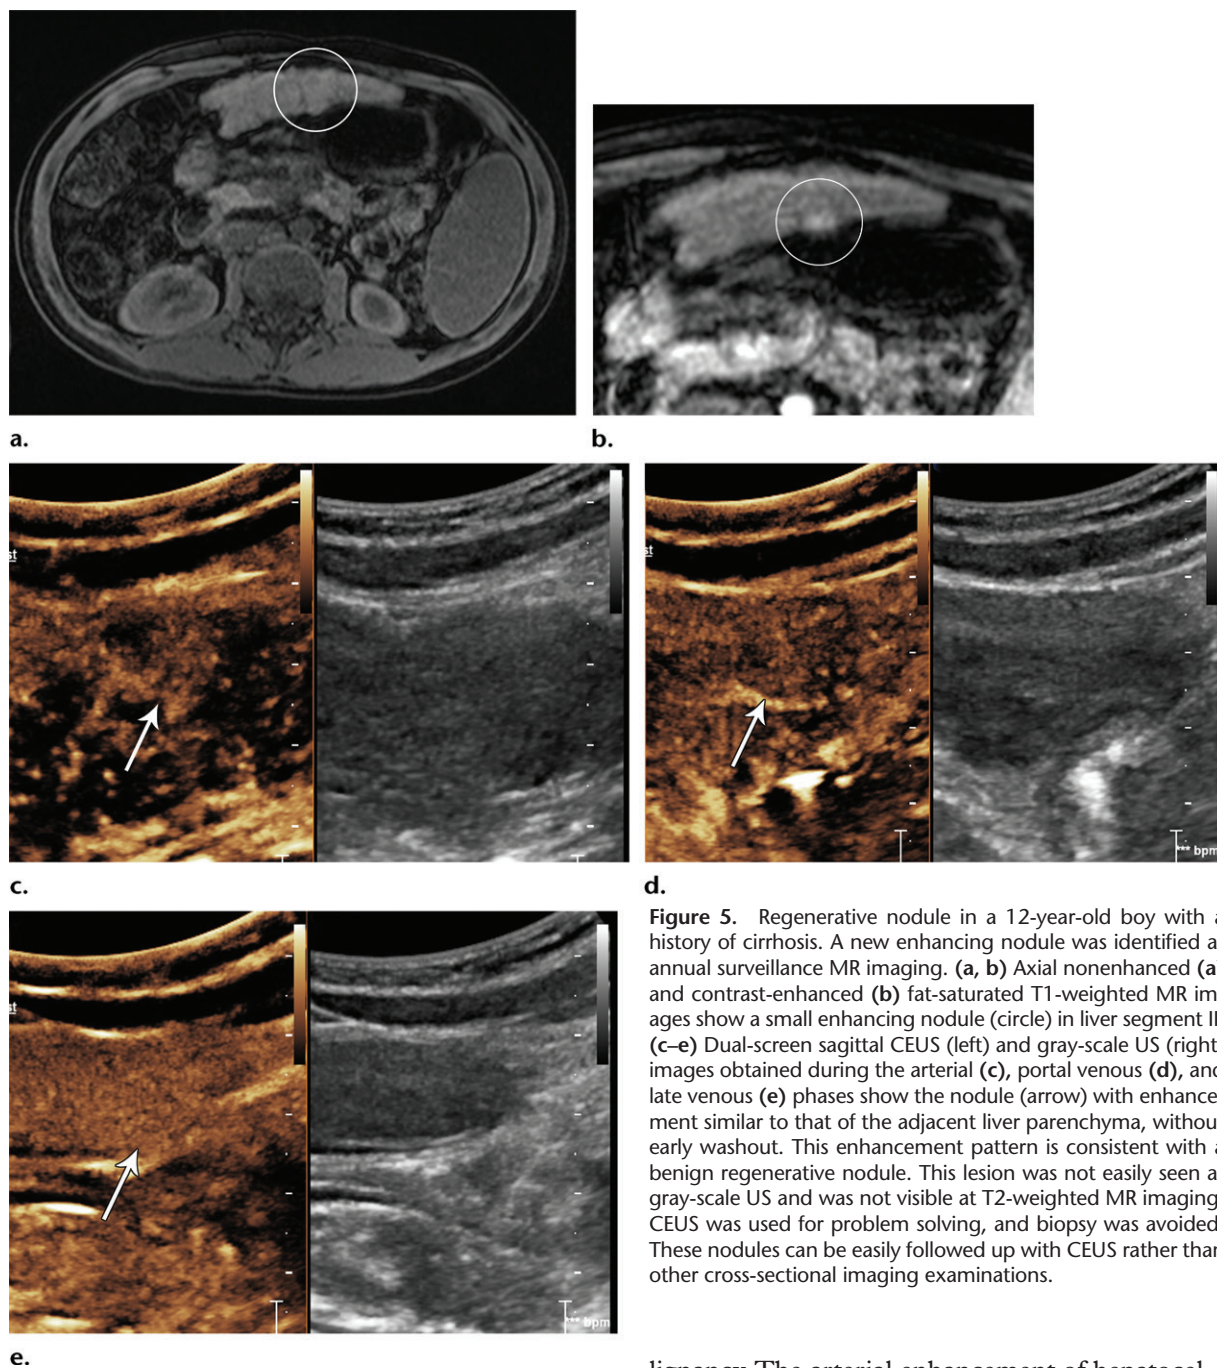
Regenerative nodule in a 12-year-old boy with a history of cirrhosis. A new enhancing nodule was identified at annual surveillance MR imaging. (a, b) Axial nonenhanced (a) and contrast-enhanced (b) fat-saturated T1-weighted MR images show a small enhancing nodule (circle) in liver segment II. (c–e) Dual-screen sagittal CEUS (left) and gray-scale US (right) images obtained during the arterial (c), portal venous (d), and late venous (e) phases show the nodule (arrow) with enhancement similar to that of the adjacent liver parenchyma, without early washout. This enhancement pattern is consistent with a benign regenerative nodule. This lesion was not easily seen at gray-scale US and was not visible at T2-weighted MR imaging. CEUS was used for problem solving, and biopsy was avoided. These nodules can be easily followed up with CEUS rather than other cross-sectional imaging examinations.
